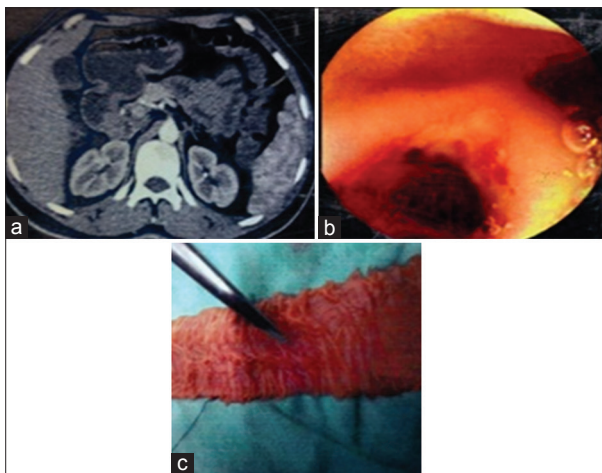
A 70-year-old male with recurrent malena. (a) Normal computed tomography enterography (b) capsule endoscopy reveals multiple ulcers in ileum (c) surgery revealed small ulcers in ileum
